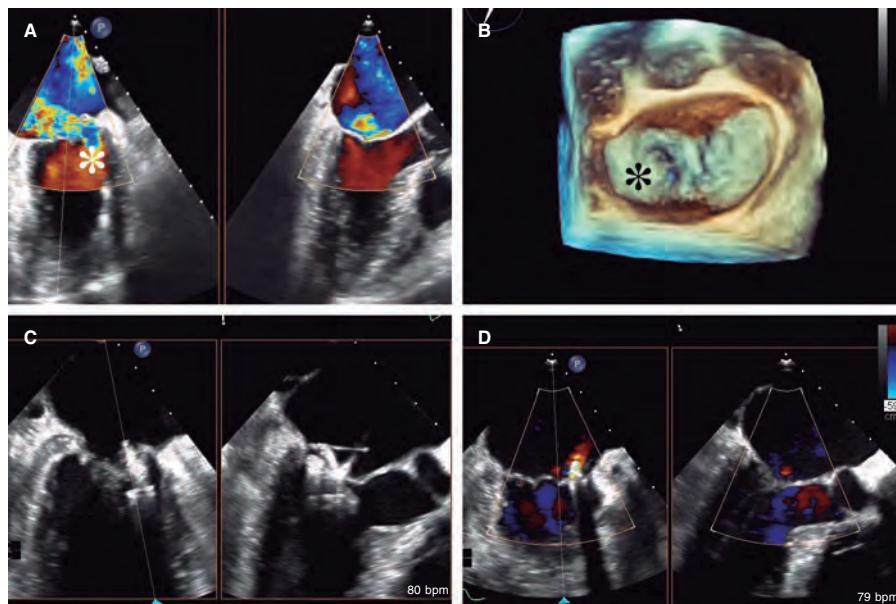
PASCAL Ace device implantation in a patient with complex mitral regurgitation. A: bi-plane color Doppler transesophageal echocardiography imaging. B: 3D reconstruction of the mitral valve showing the P1 eversion (asterisks) accompanied by a significant jet towards the septum. C: final clasping of the leaflets. D: very mild final regurgitant jet.
